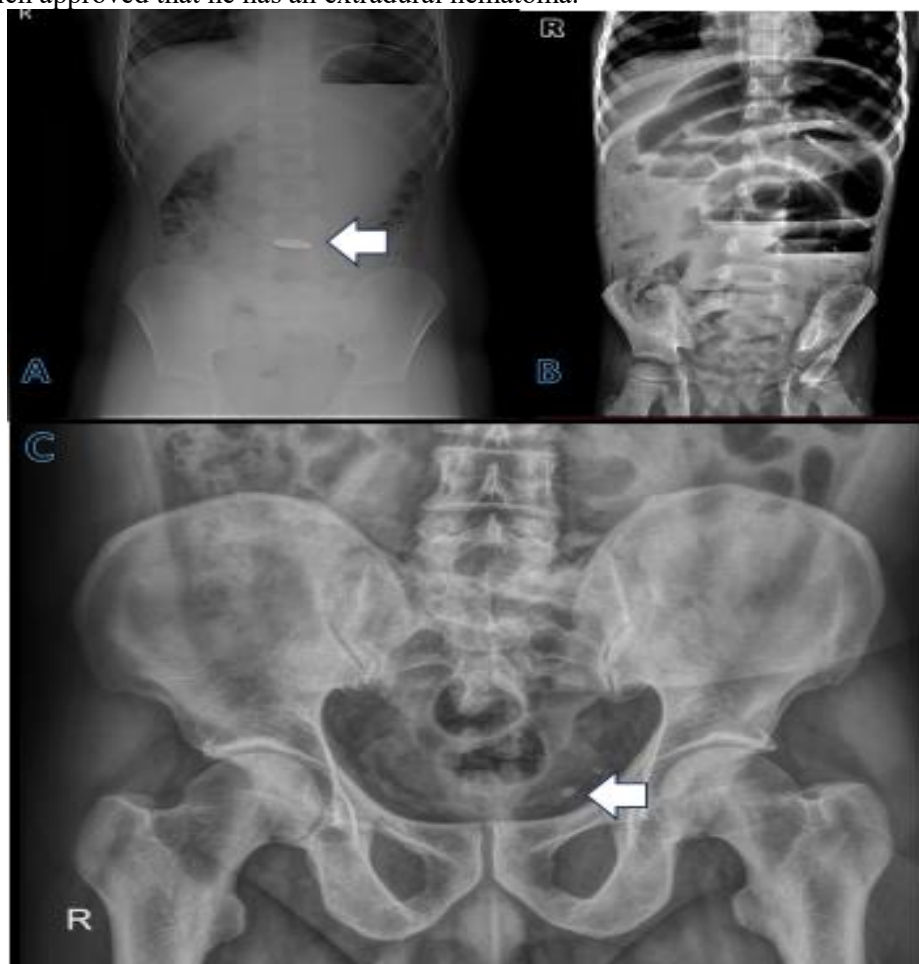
A- Female patient (7 months) ingested foreign body; X-ray abdomen AP view shows metallic FB at the lower abdomen. B- Female child 4 y, presented with absolute constipation, X-ray Abdomen erect position shows multiple air fluid levels (Intestinal Obstruction) C- X ray pelvis-AP view of a patient presented with Lt loin pain; it shows Lt distal ureteric 2 variable size calicular shadows. Diagnosis confirmed by CT scan was done in another hospital.
